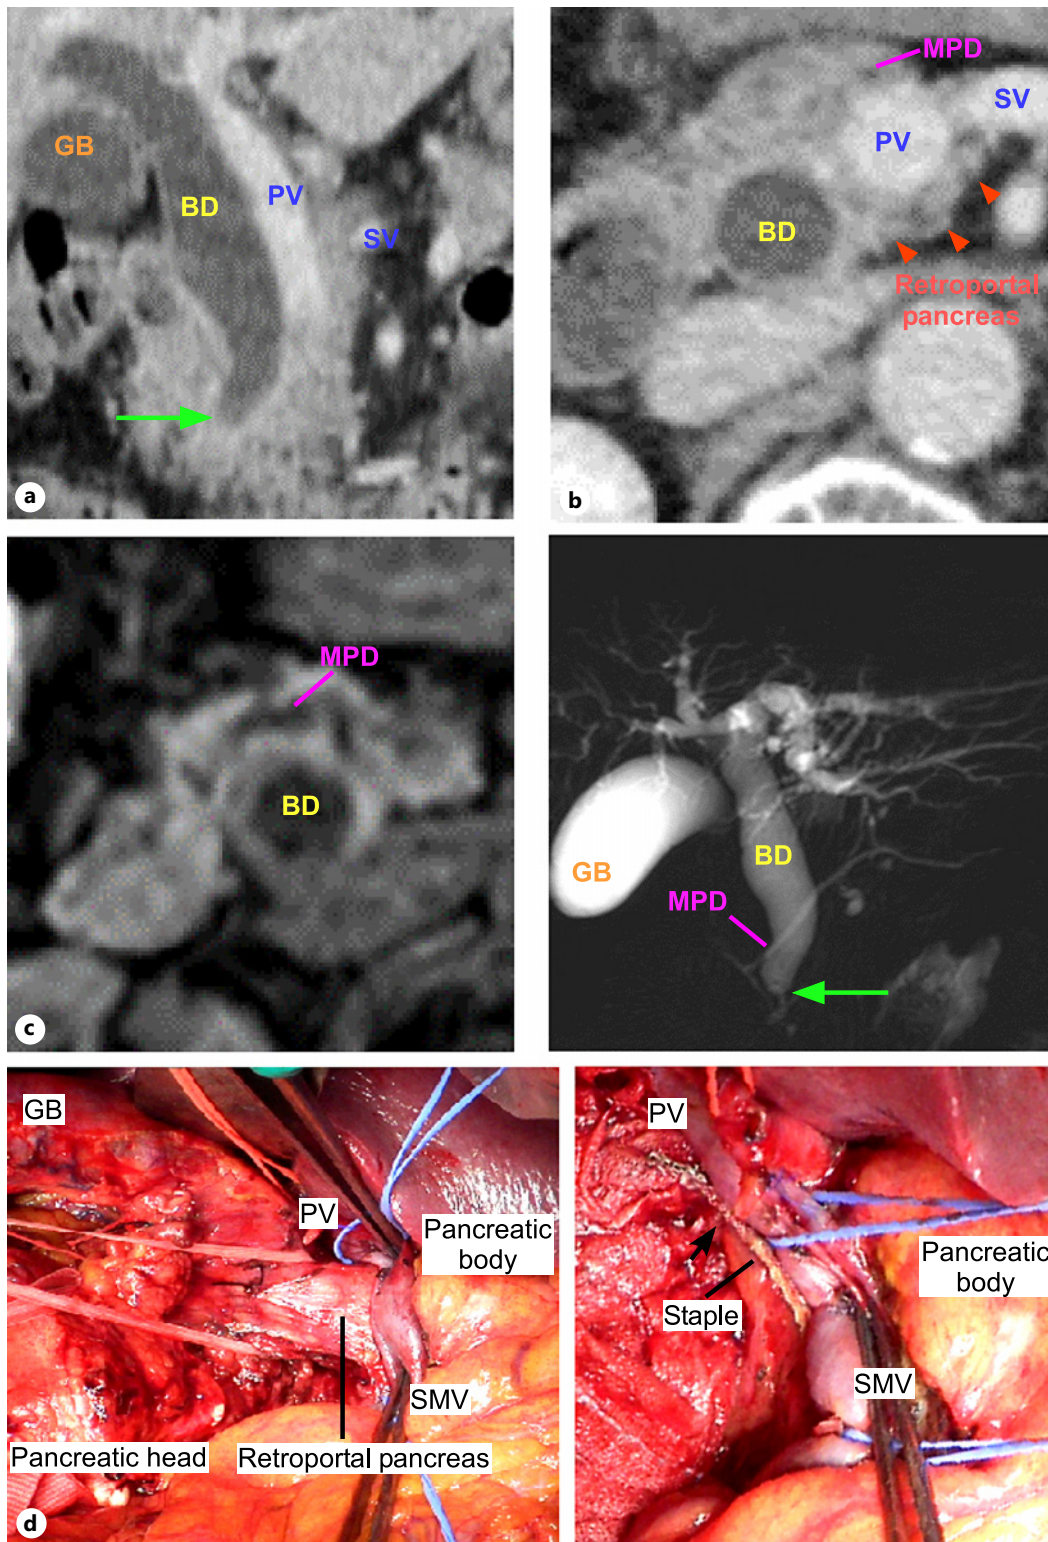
CT images and intraoperative findings in case 1. a Axial view. CT imaging showed enhancement of the tumor in a distal BD (arrows). b Intraoperative finding of PAP after resection of the anteportal pancreas just above the PV. The retroportal pancreas could not be separated from the uncinate process. c Sagittal view. An existence of the PAP found from the CT image. BD, bile duct; CT, computed tomography; GB, gallbladder; MPD, main pancreatic duct; PAP, portal annular pancreas; PV, portal vein; SMV, superior mesenteric vein.
